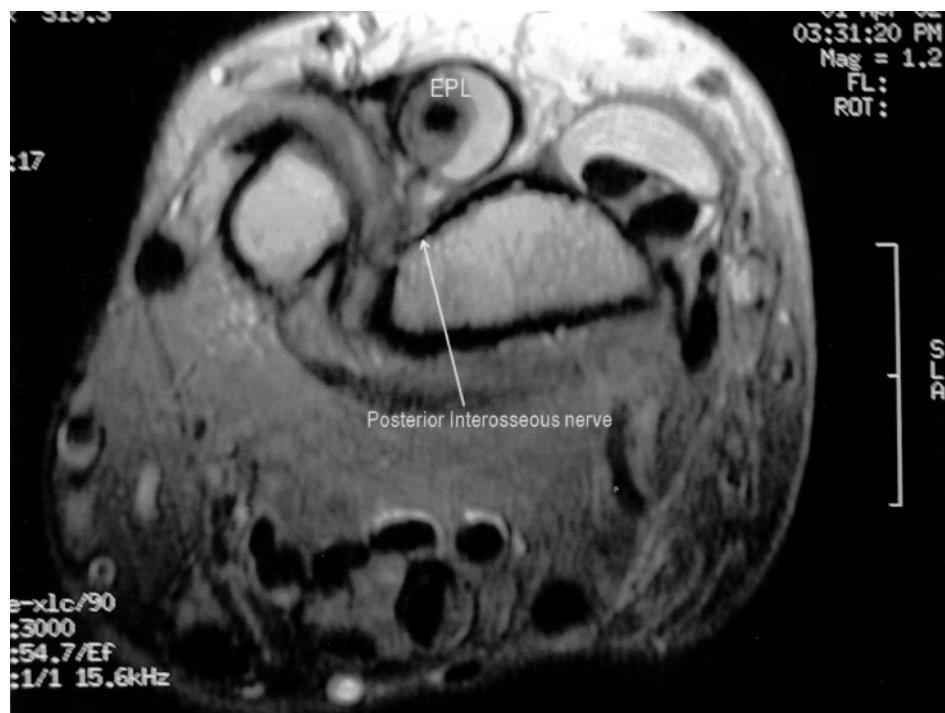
MRI reveals the posterior interosseous nerve compressed by a bulging synovial cyst of the extensor pollicis longus (EPL) tendon.
